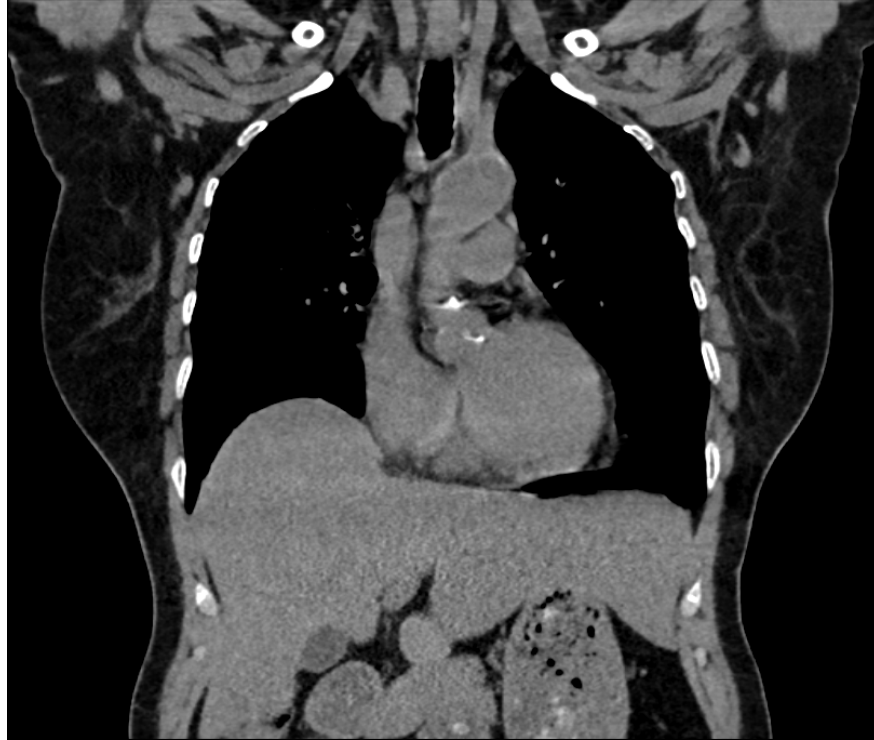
Plain CT of chest Mediastinal window in Coronal plane
